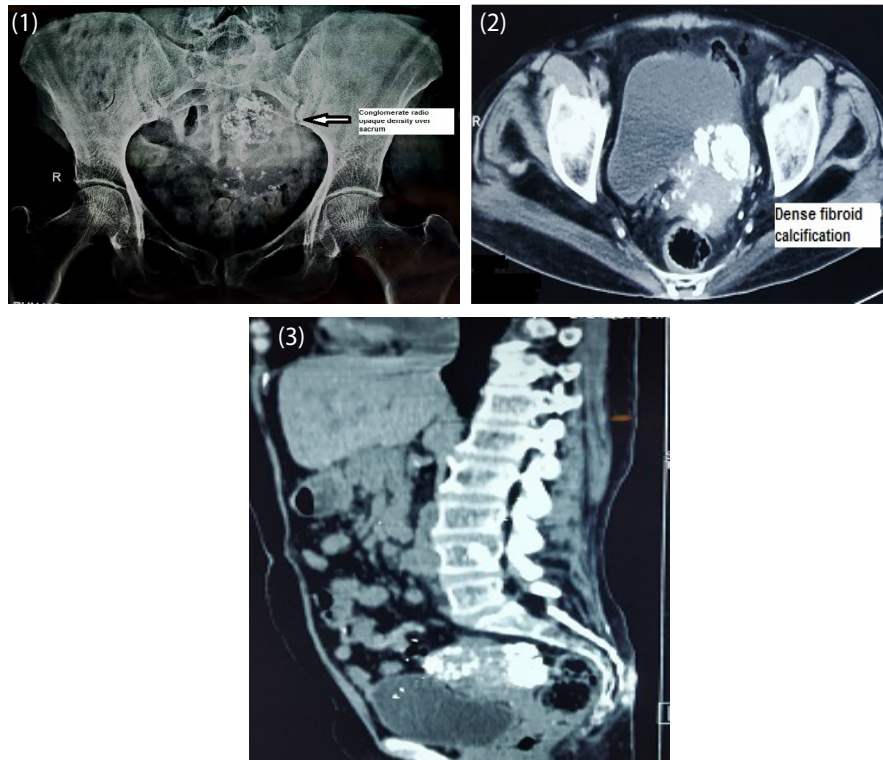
X-ray pelvis showing conglomerate radio opaque density deposits in the pelvis over the sacral bone.
